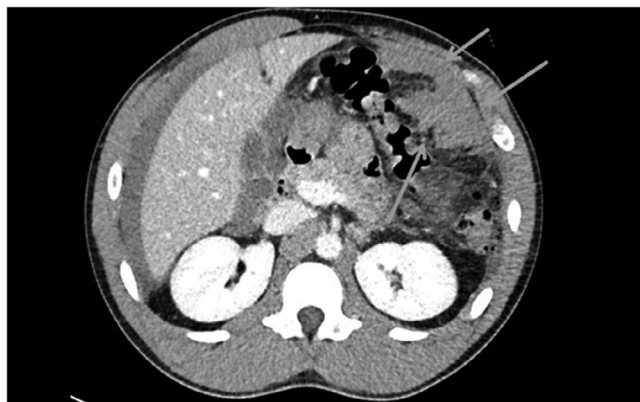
Cross sectional computed tomography (CT) scan of patient's abdomen showing idiopathic omental hemorrhage (IOH).
